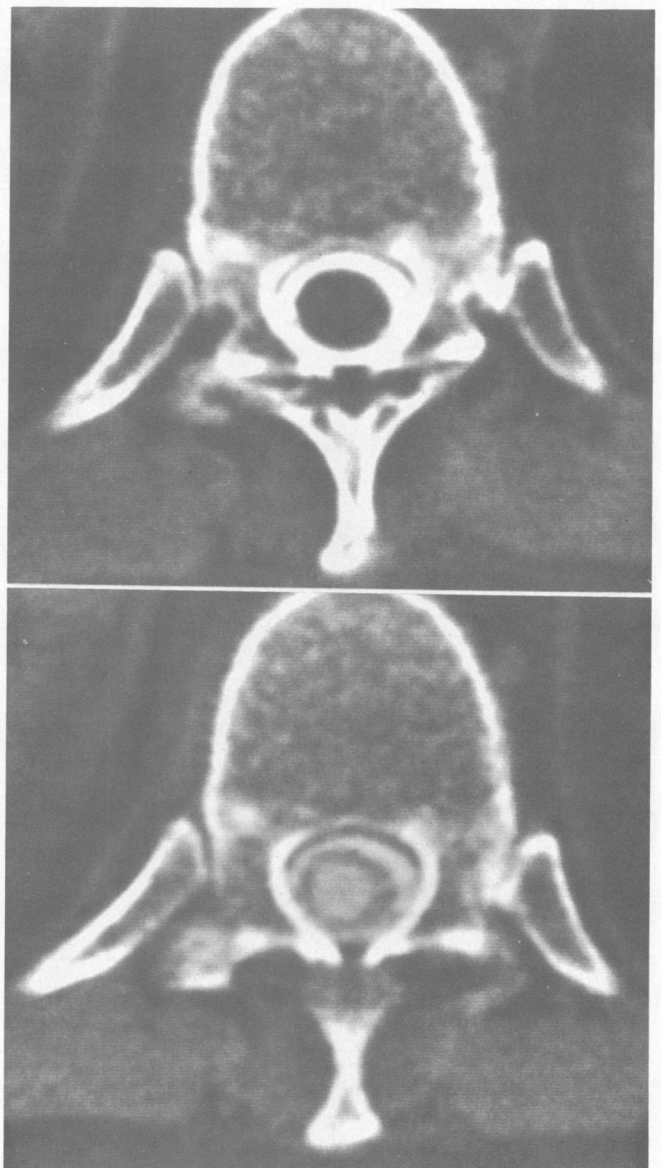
Case 5: A computed tomographic (CT) scan after metrizamide myelography shows (top) an enlarged thoracic cord. A delayed CT scan (bottom) shows uptake of contrast within the intramedullary cyst.
